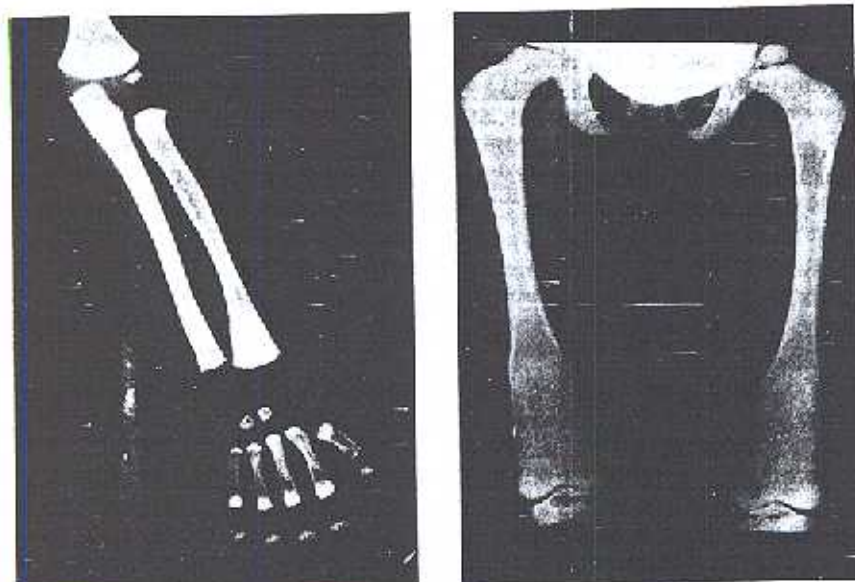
Radiographs of patients with osteopetrosis, showing generalized sclerosis of bones, with metaphysis widening and cortical thickening.
